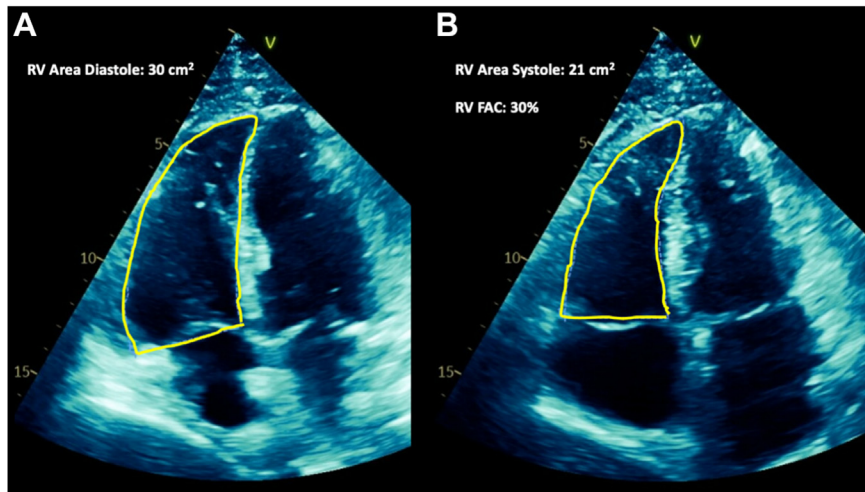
Two-dimensional TTE with B-mode colorization, RV-focused apical 4-chamber view in (A) end diastole and (B) end systole, demonstrates RV enlargement and mildly reduced systolic function by fractional area change (FAC).
